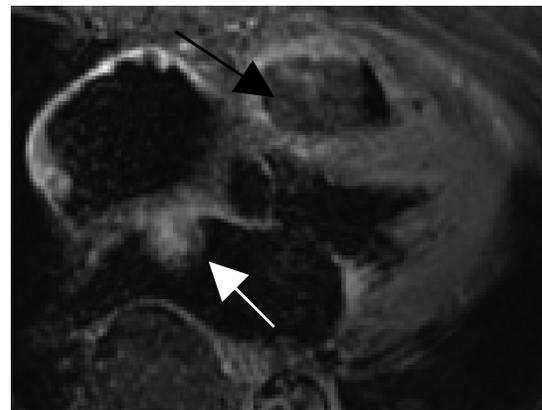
Axial T1-weighted fat-saturated spin echo image post contrast. The RVOT mass (dark arrow) remains of low signal while the left atrial mass (light arrow) clearly enhances.
